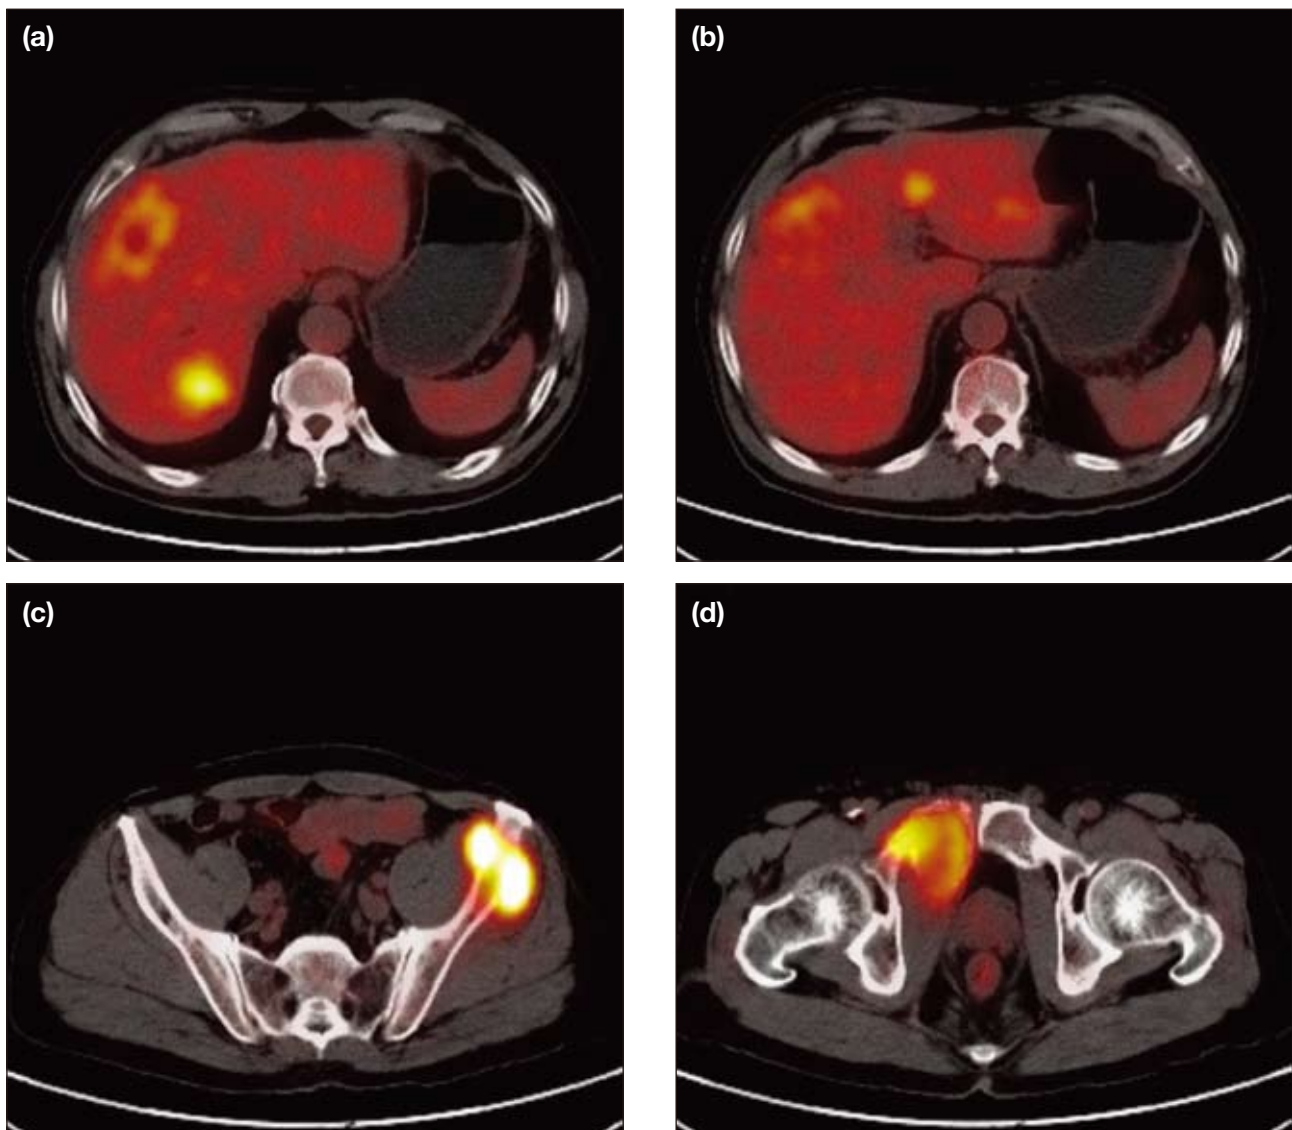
F-18 fluorodeoxyglucose positron-emission tomography computed tomography images showing multiple hypermetabolic lesions involving (a and b) both lobes of the liver; (c) the left iliac crest; and (d) the right superior pubic ramus.
